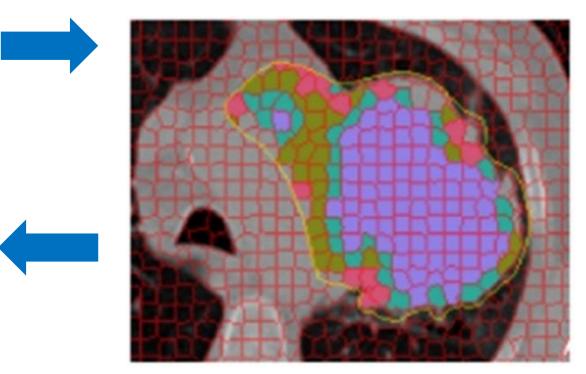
Identification of tumor phenotypes based on radiomics methods, such as CT number, hypoxia and vascularity [Even et al. 2017].
